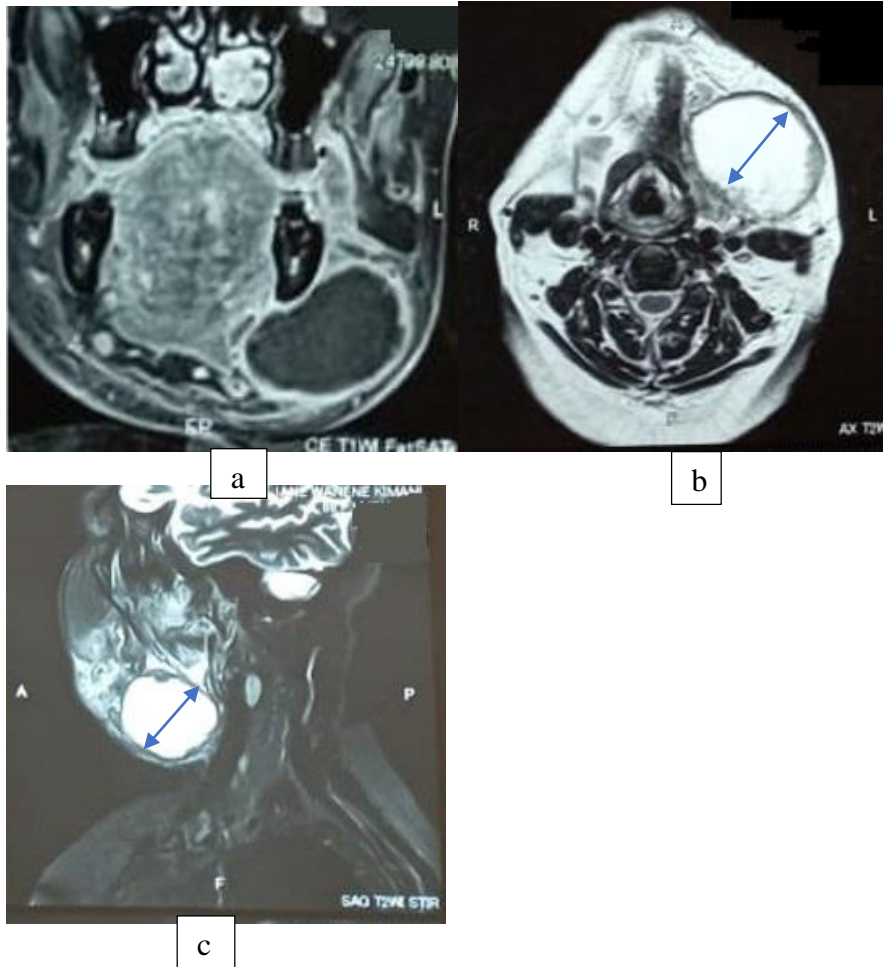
2 Magnetic Resonance Imaging from the study showing a large necrotic node; a) Coronal Contrast enhanced T1-Weighted with fat saturation, b) Axial T2-Weighted, c) Sagittal T2-Weighted -Short-Tau Inversion Recovery
